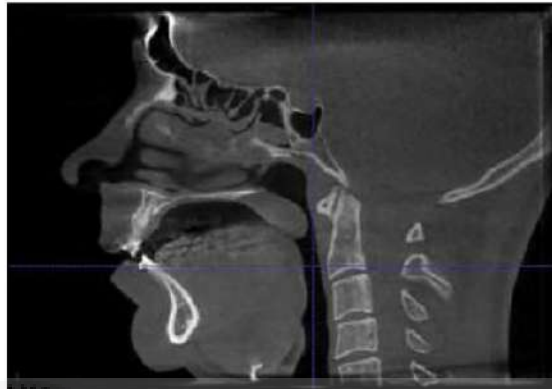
Presurgery CBCT scan and midsagittal view (patient 2)
